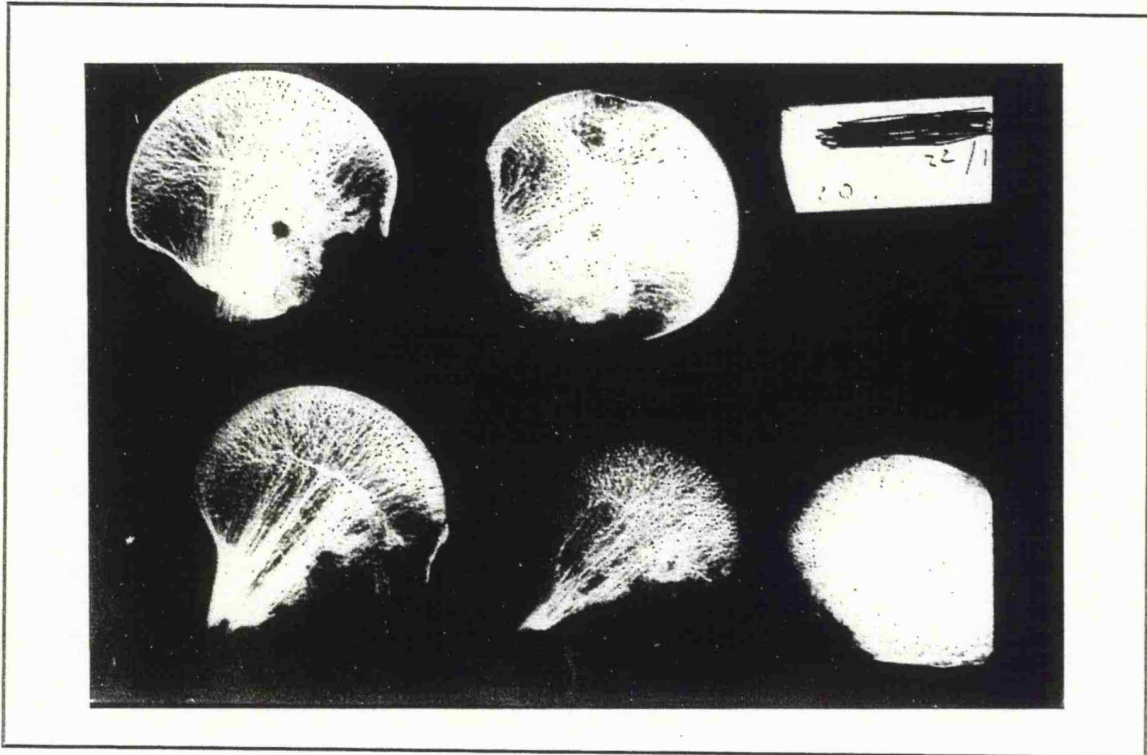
Slab radiograph of sagittal slices of a femoral head following fracture showing the common pattern of the fracture line in intracapsular proximal femoral fractures.
